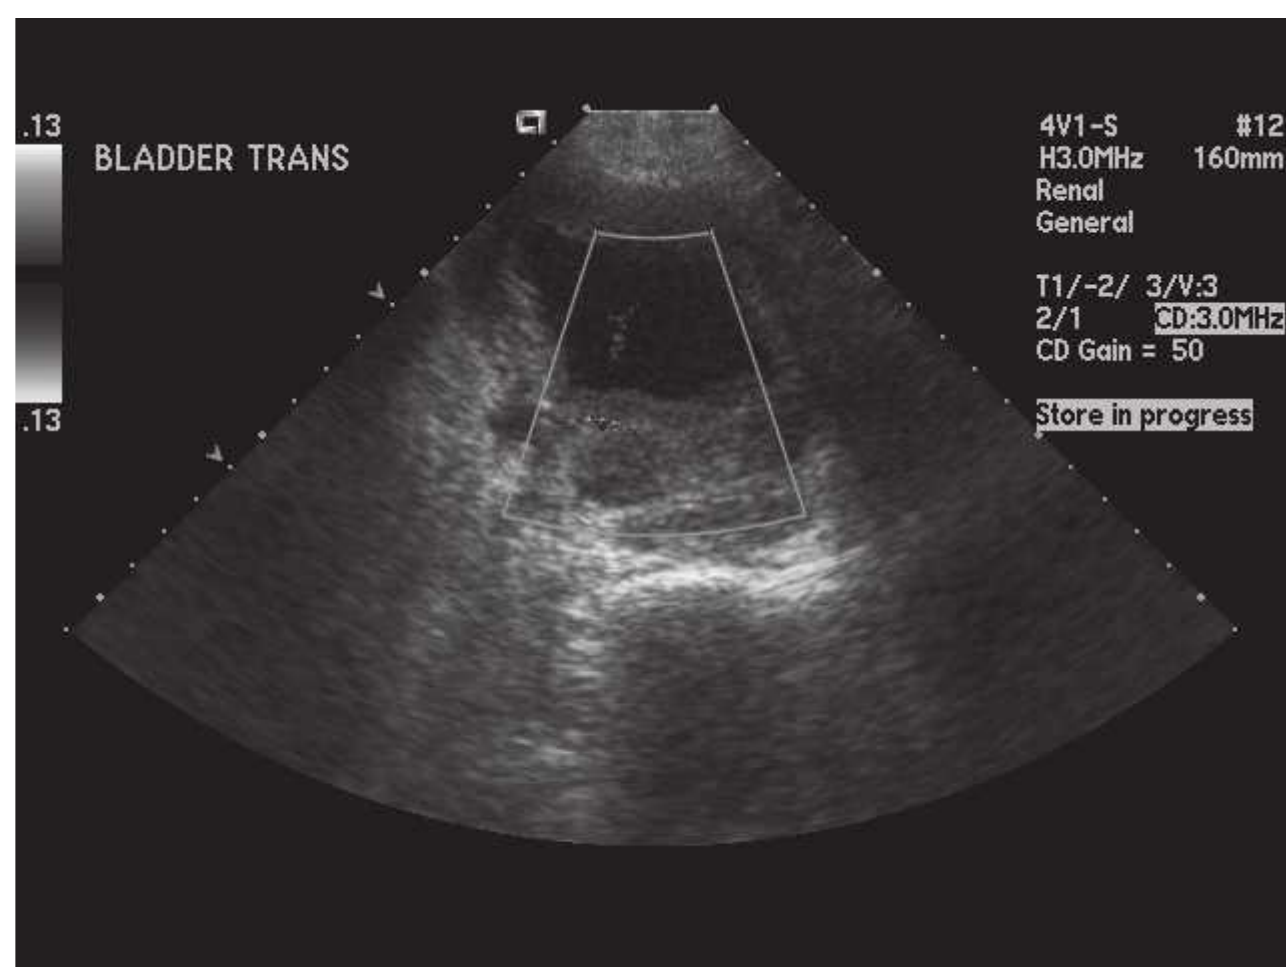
A fully distended bladder is shown here on ultrasound from a bladder outlet obstruction. Notice the thickened bladder wall circumferentially, which is often seen from a prolonged outlet obstruction from the prostate.
